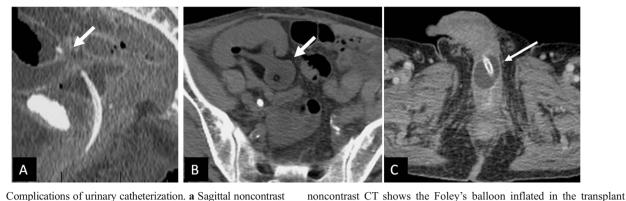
Complications of urinary catheterization. a Sagittal noncontrast CT shows bladder perforation following Foley's catheterization with the tip of the catheter seen in the adjacent bowel loop (*arrow*). b Axial
